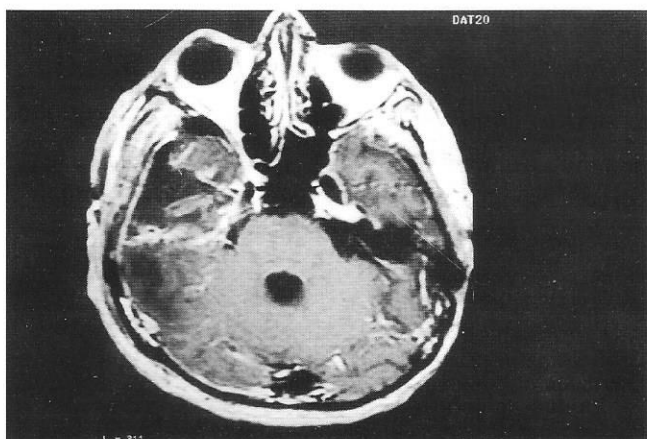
Postoperative magnetic resonance image showing gross total resection of the tumor.
